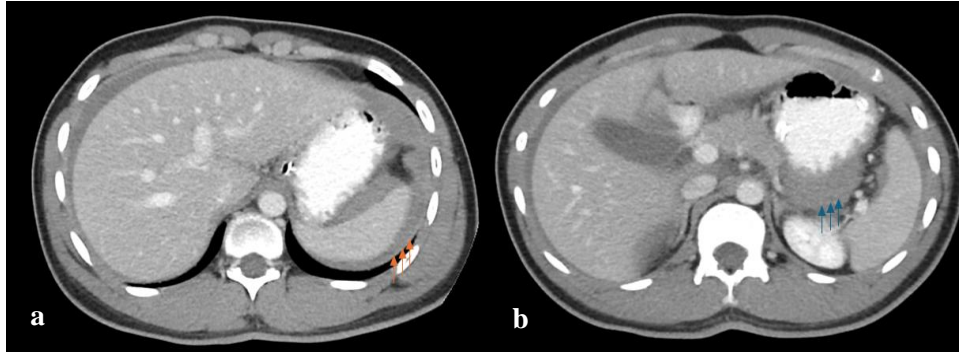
(a) & (b): Contrast enhanced computed tomography of the abdomen shows free fluid at perisplenic (orange arrow) and lesser sac (blue arrow)
